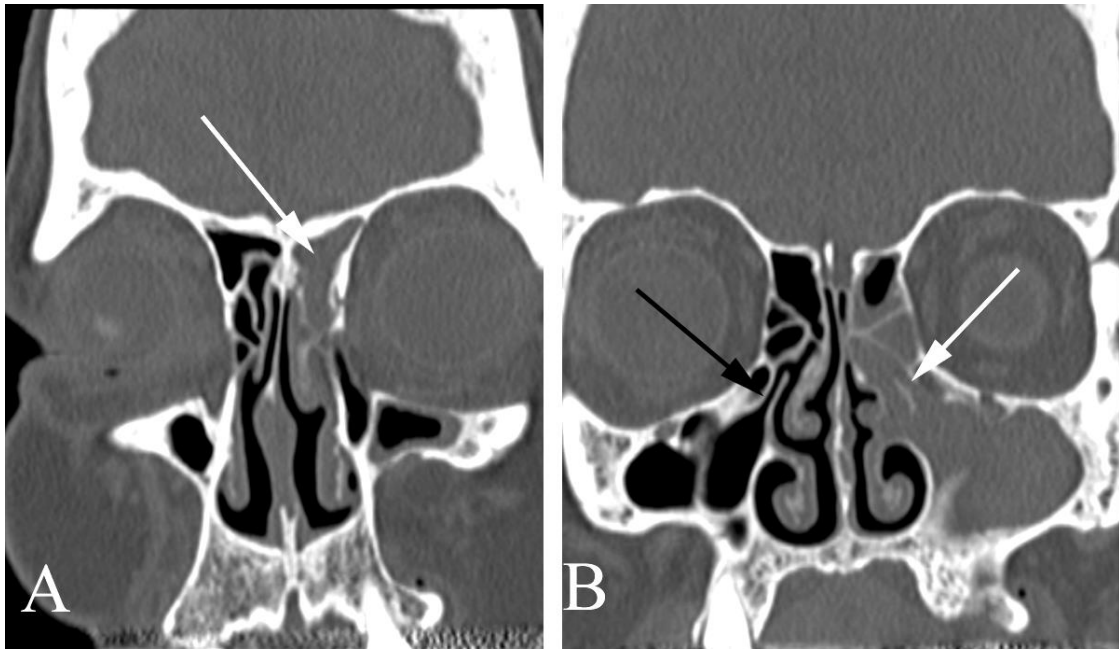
Sinusitis demonstrating an “ostiomeatal unit” pattern of infection in a 76 year old with chronic headache and nasal drainage. A. Coronal sinus CT (bone windows) shows opacification of left ethmoidal air cells (arrow). B. Coronal sinus CT (bone windows) at a more posterior location shows opacification of the left maxillary sinus including complete occlusion of the ostiomeatal unit (white arrow). Note the normal, open appearance of the contralateral ostiomeatal unit (black arrow).
